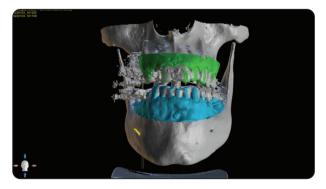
Superimposition of CBCT with STL to fabricate the guide.
